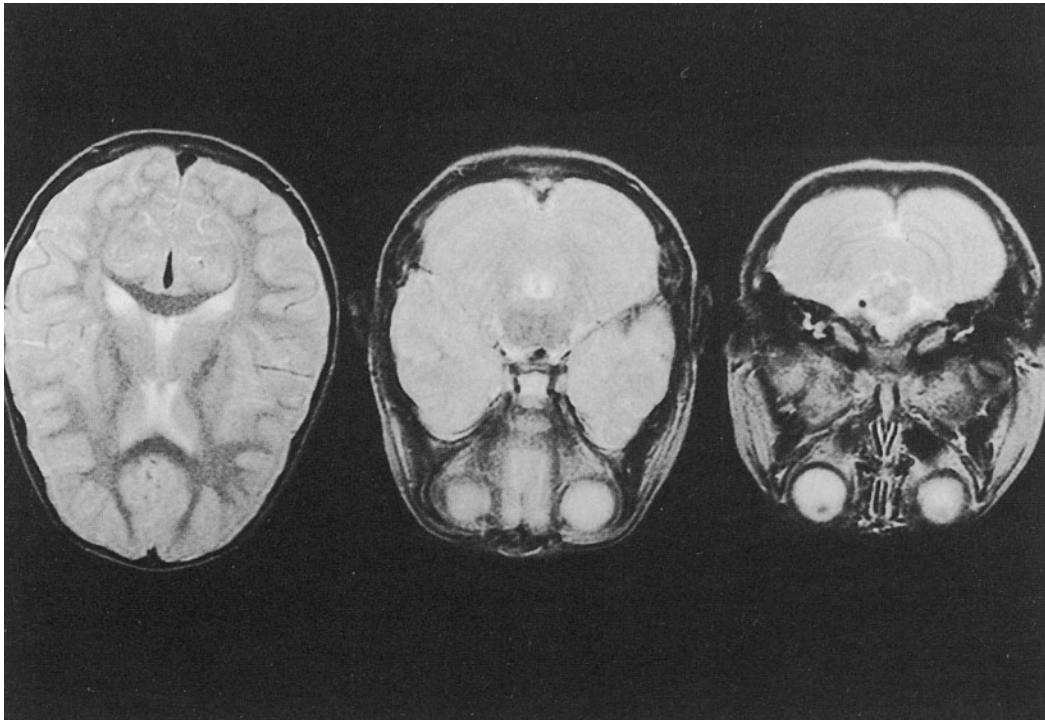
Brain MRI T2-weighted scan performed at 2 months later since the onset of ADEM shows disappearance of the areas of high signal intensity.
